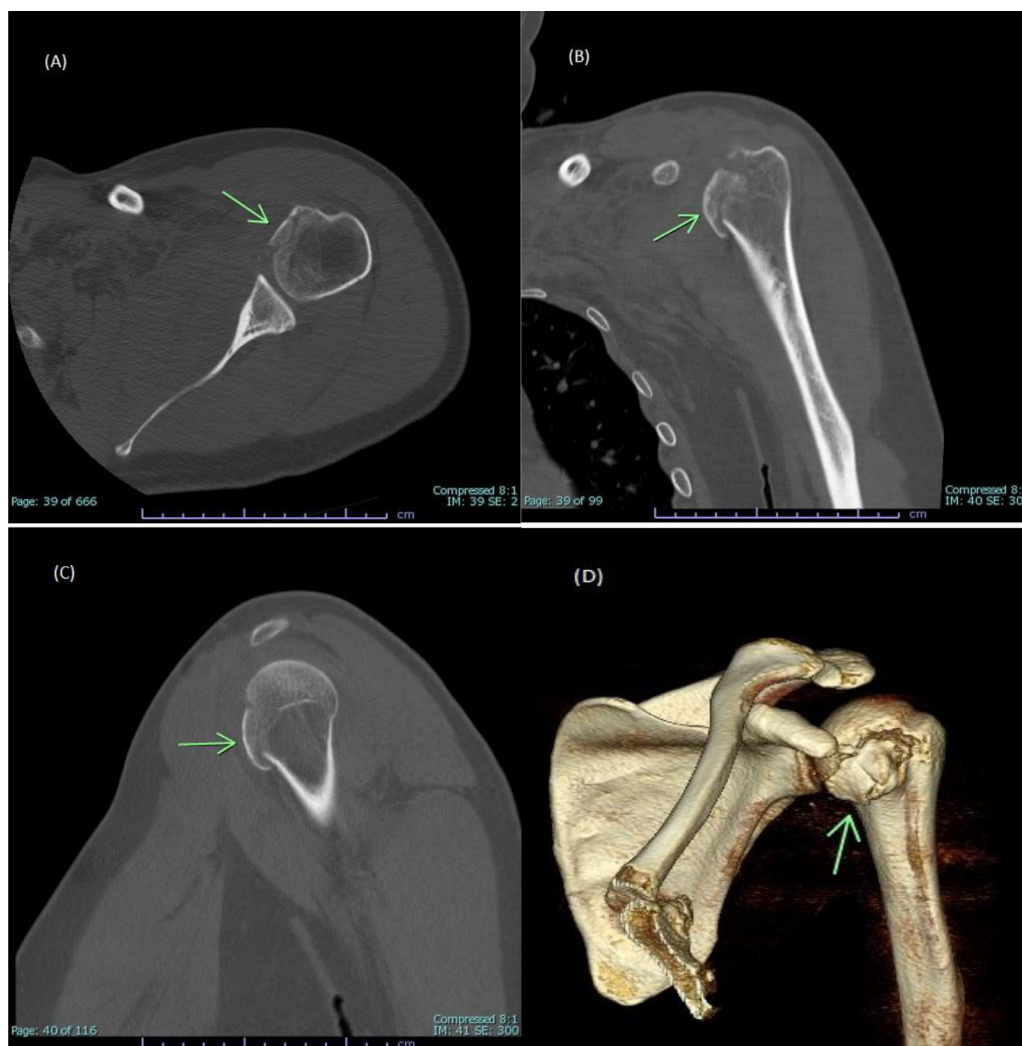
Left shoulder axial (A), coronal (B), sagittal (C), 3D volume-rendered (D) CT images showing an acute mildly displaced fracture of the lesser tuberosity.
